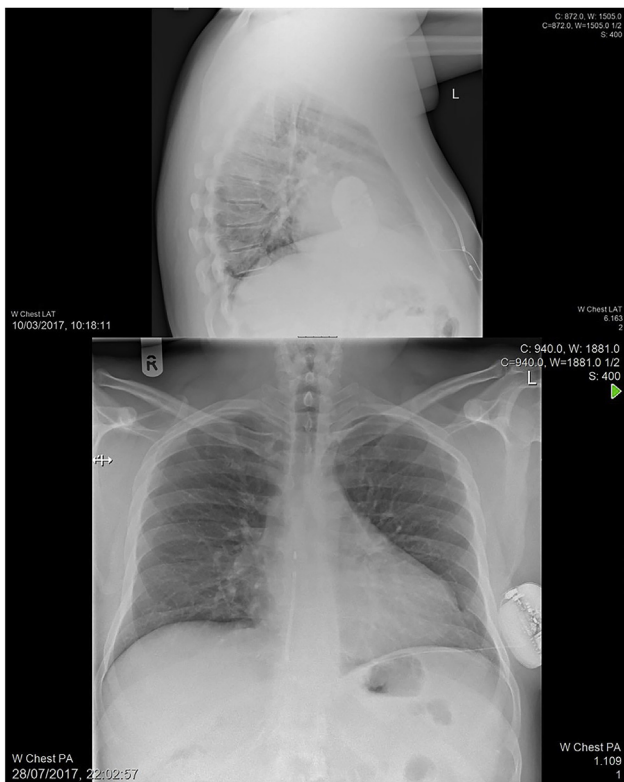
Chest radiographs showing the position of the generator and the lead. There is a significant amount of subcutaneous fat separating the lead from the sternum.
